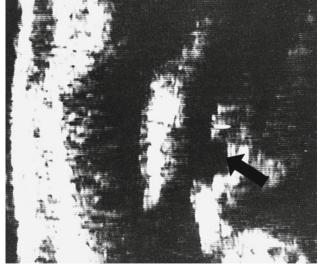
A duplex ultrasound image of the carotid bifurcation showing an ulcerative lesion of the proximal internal carotid artery (*arrow*)
